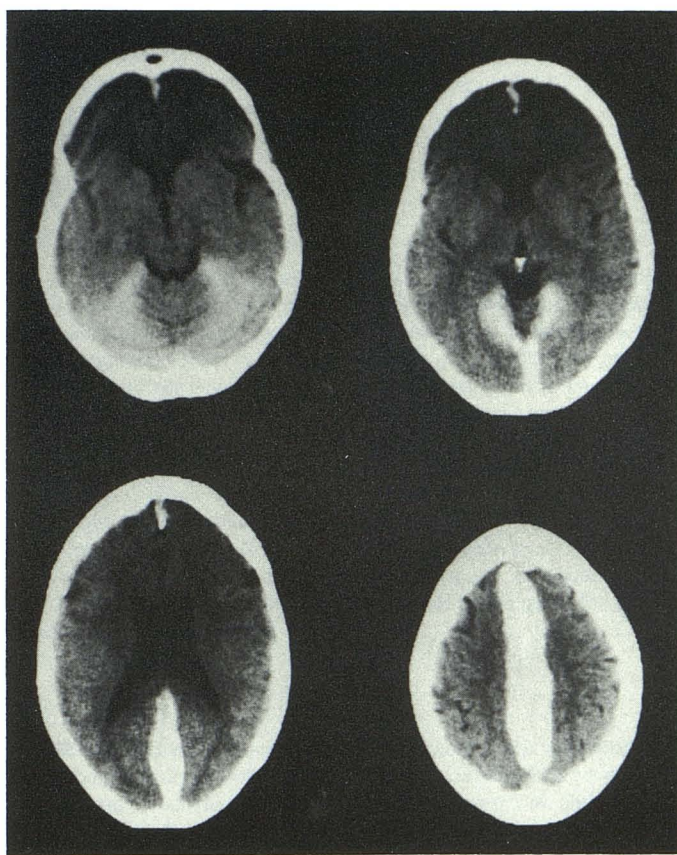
CT scans show dense interhemispheric collections of fresh blood extending down over tentorium.
